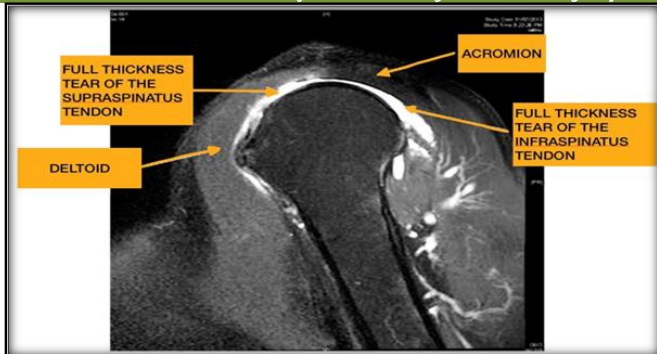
A 48 year old male with right shoulder pain, diagnosed to have full thickness tear of infraspinatus tendon. Image - MRI- T2 weighted fat suppressed Image, axial section showing full thickness tear.
